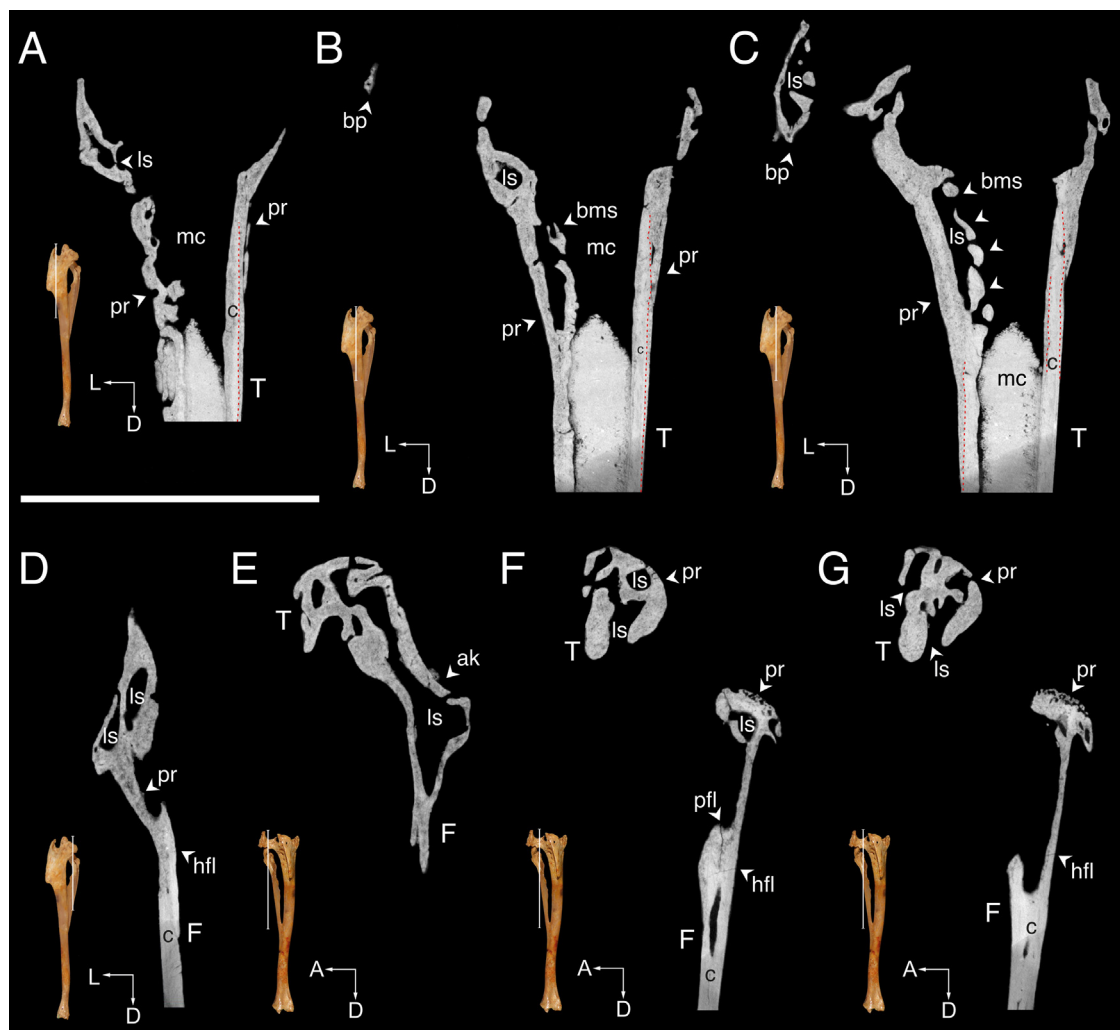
μ CT images of paleopathological region of the tibiofibular bone (1966XXXIV 3340). A–D. Coronal views. E–G. Sagittal views. Cutting lines indicate the level of the slices. The red dashed lines split the cortical bone from the periosteal reaction. A: anterior; ak: ankylosis; bms: bony micro-sequestra; bp: bony projection; c: cortical bone; D: distal; F: fibula; hfl: healed fracture line; L: lateral; ls: lacunar-like spot; mc: medullary cavity; pfl: postmortem fracture line; T: tibia; pr: periosteal reaction. The scale bar represents 5 mm.
